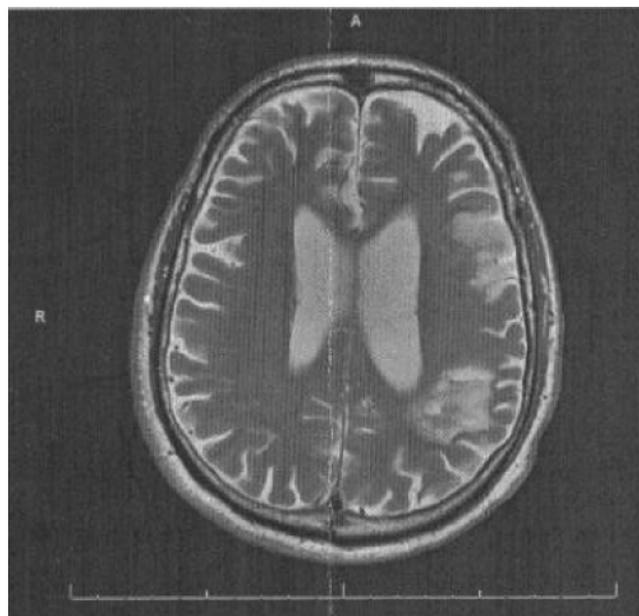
MRI of patient performed 5/2/2013 reveals two infarcts, a chronic left posterior parietal infarct and an acute left frontal infarct.
